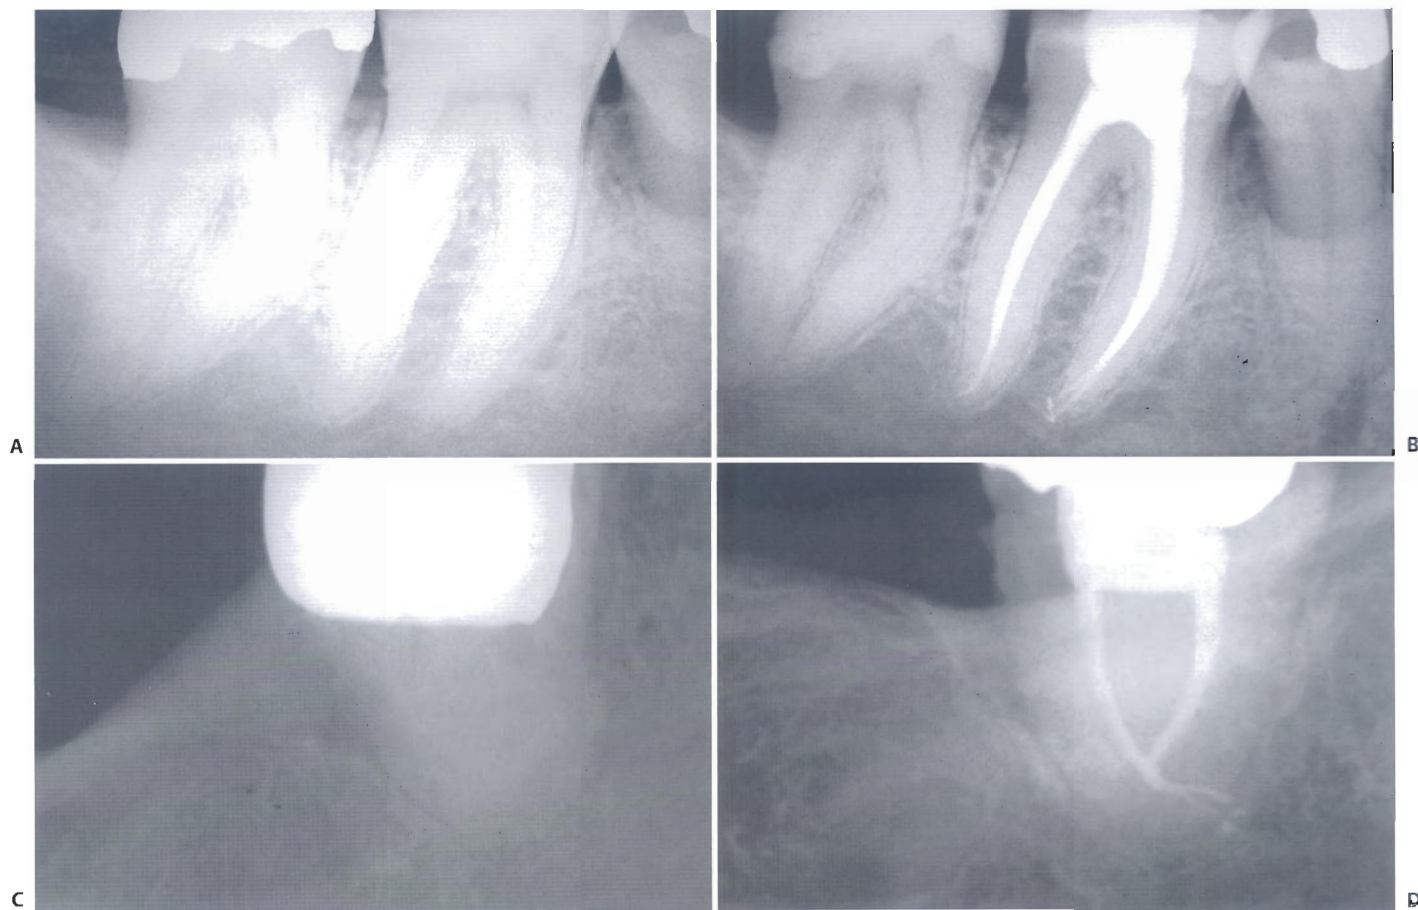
Clinical cases of teeth with calcified canals. In these cases it is very important to have an adequate manual preflaring to reduce torsional stresses. A. Preoperative radiograph of the lower right first molar. B. Post operative radiograph (E. Berutti). C. Preoperative radiograph of the lower left third molar. D. Postoperative radiograph (G. Cantatore).
